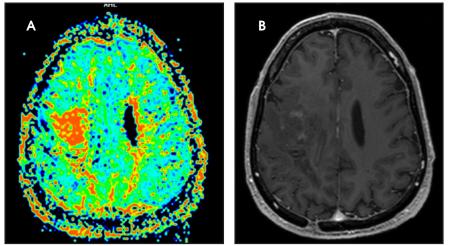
This is a 54-year-old male (A) with a right frontal low-grade astrocytoma noted to have accelerated progression of the tumor 17 years after initial diagnosis. MRI (B) with contrast (bottom image) shows increased patchy enhancement in the right frontotemporal mass. There is increased CBV in the same area with a rough relative CBV ratio of 3.0:3.5, compared to the contralateral cerebral white matter indicating tumor progression (top image).
